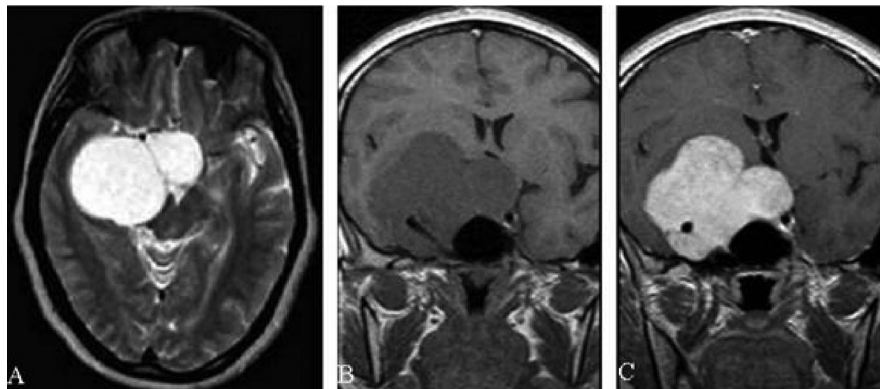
(A) Axial T2-weighted MR image reveals a well-circumscribed, large, lobulated, markedly hyperintense lesion in the right cavernous sinus with mass effect on the midbrain. (B) Coronal T1-weighted MR image shows a well-circumscribed, large, lobulated, hypointense lesion in the right parasellar region with encasement of the right internal carotid artery and sellar extension. (C) Coronal T1-weighted postgadolinium MR image shows an intense and homogenous enhancement of the lobulated right cavernous sinus lesion.
